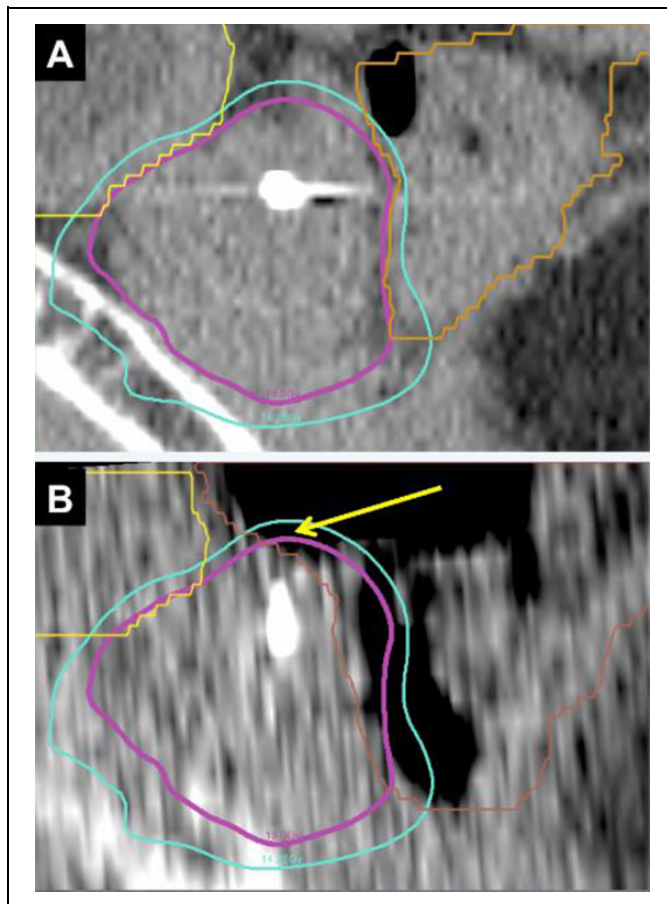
Example patient (#5) demonstrating variable rectal position and received dose without prostate rotation or deformation. Parasagittal view of the prostate, rectum, and bladder shown on (A) stereotactic body radiotherapy (SBRT) planning computed tomography (CT) and (B) daily megavoltage computed tomography (MVCT) during external beam radiotherapy. For both images, the rectal contour is shown in brown, the bladder contour is shown in yellow, the prescription isodose line (19 Gy) is shown in magenta, and the 75% isodose line (14.25 Gy) is shown in teal. The yellow arrow denotes a region of gas-filled rectum projecting superior to the prostate seen on MVCT, which yields a significant portion of the rectum receiving over 75% of prescription dose. This region was not contoured as part of the rectum on planning CT. For this MVCT, the prostate rotation (pitch) was 4.3°, maximum rigid body error (RBE_{max}) was 2.28 mm, and rectal and bladder V75% were 14.97 and 7.64 cm³, respectively. Note: The color version of the figure is available at journals.sagepub.com/home/tct
